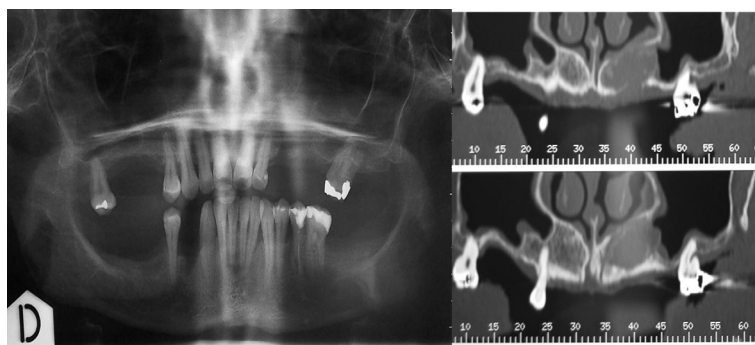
OPT and CT follow-up, 6 months after surgery.
